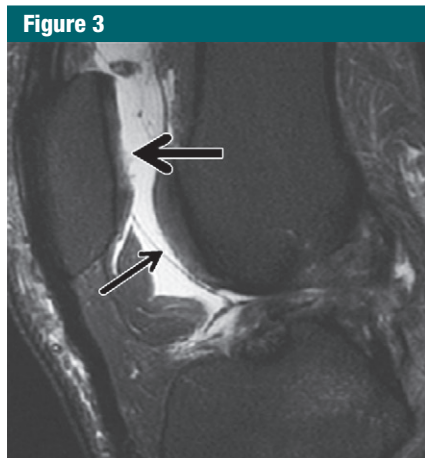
Images in 46-year-old woman with surgically confirmed grade 2B cartilage lesion on patella (classified as MR grade 2B cartilage lesion) and surgically confirmed grade 1A cartilage lesion on trochlea (classified as MR grade 1A cartilage lesion). (a) Sagittal fat-suppressed T2-weighted fast spin-echo image shows partial-thickness cartilage lesion on patella (large arrow) but normal-appearing articular cartilage on trochlea (small arrow). (b) Corresponding sagittal T2 map shows areas of increased T2 relaxation time on patella (large arrow) and trochlea (small arrow).
